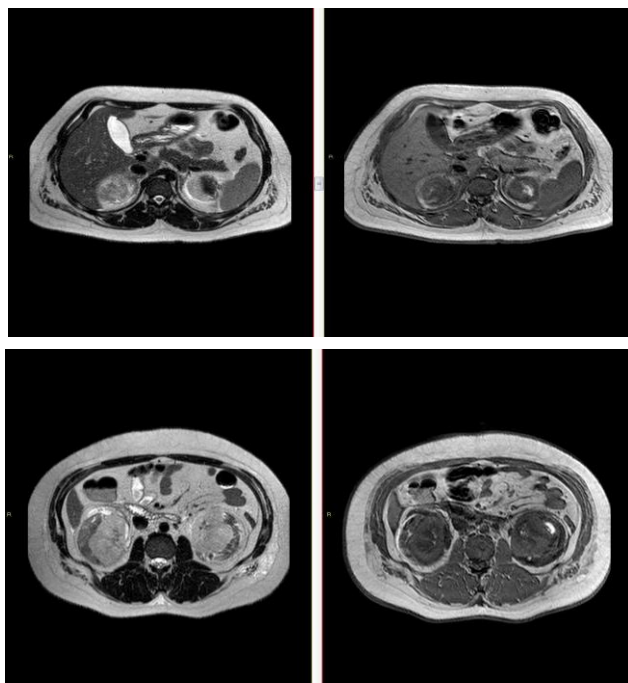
A (upper) and B (lower). Upper Abdominal MRI with 1.5 Tesla implant, on axial planes, T2-weighted sequences on the left and T1-weighted sequences on the right.
